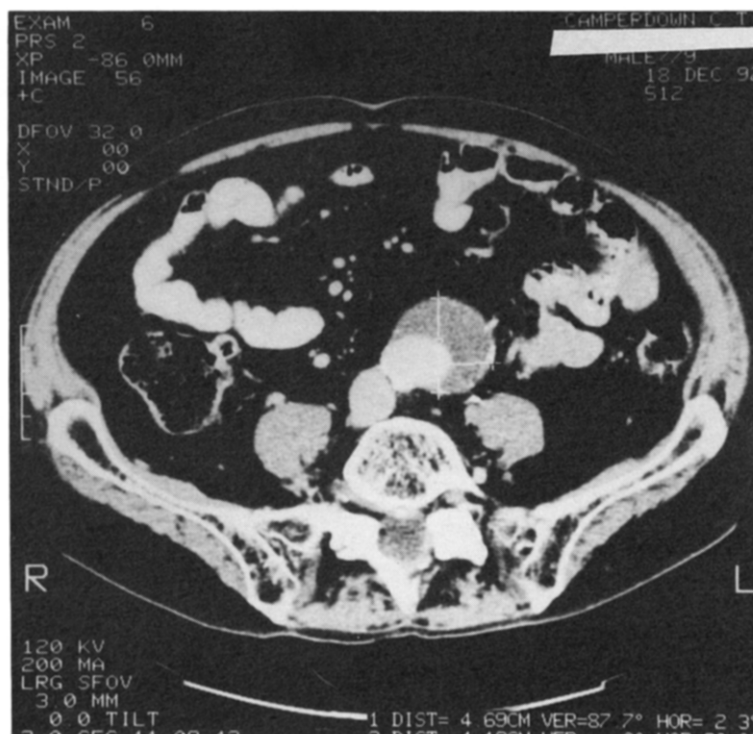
CT scan 0.5 cm above aortic bifurcation from case 1, confirms extent of aneurysm and absence of distal neck.
